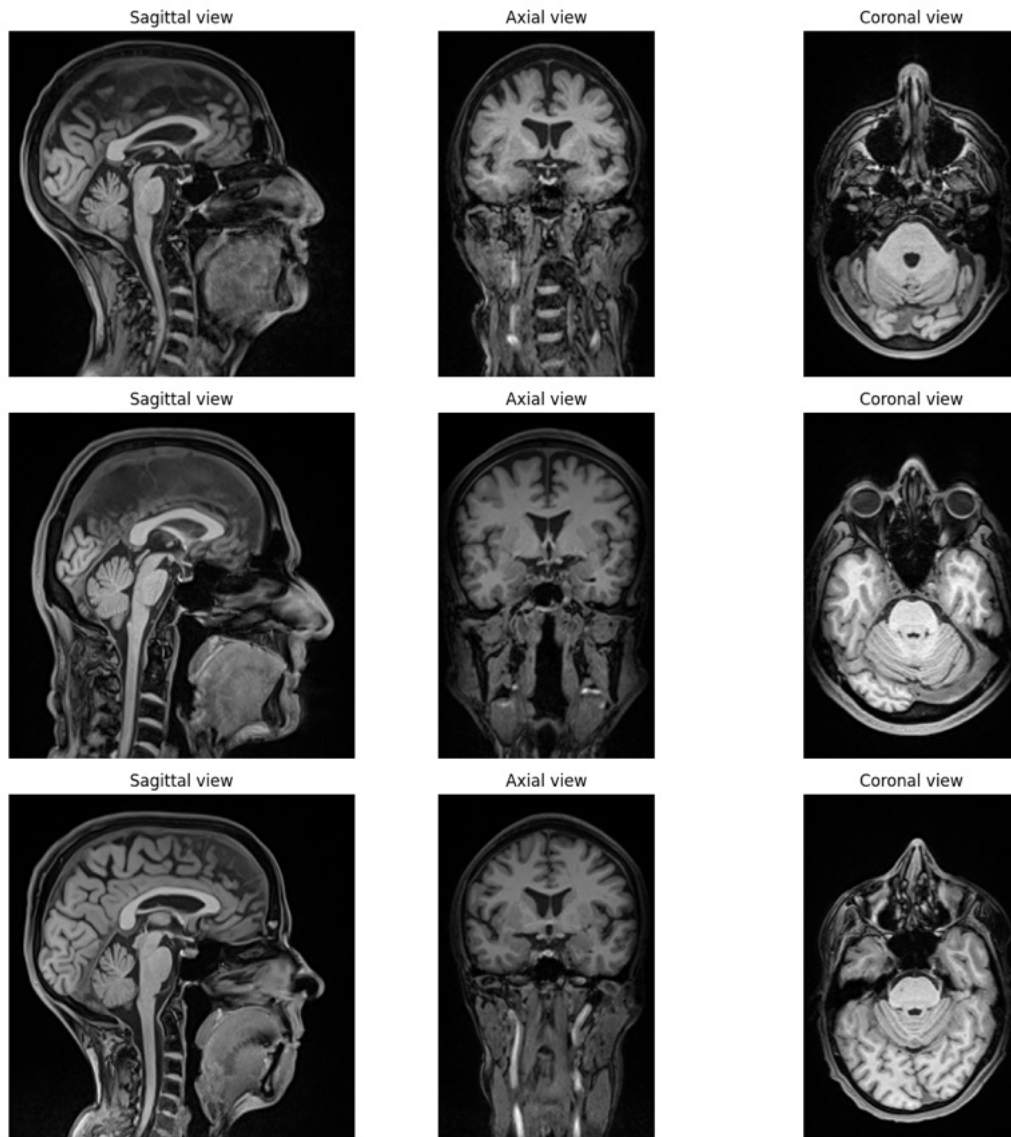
MRI scans from different subjects, displaying slices from the three axial views of their brain: sagittal, axial and coronal perspectives.
